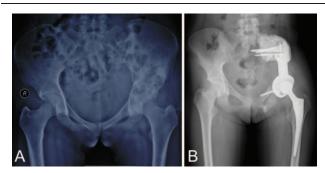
Patient's x-rays. (A) Preoperative plain film showing left hemipelvis: zone I-II-IV involvement. (B) Postoperative plain film showing that the prosthetic positioning is good, with no loosening, fracture, or dislocation.
